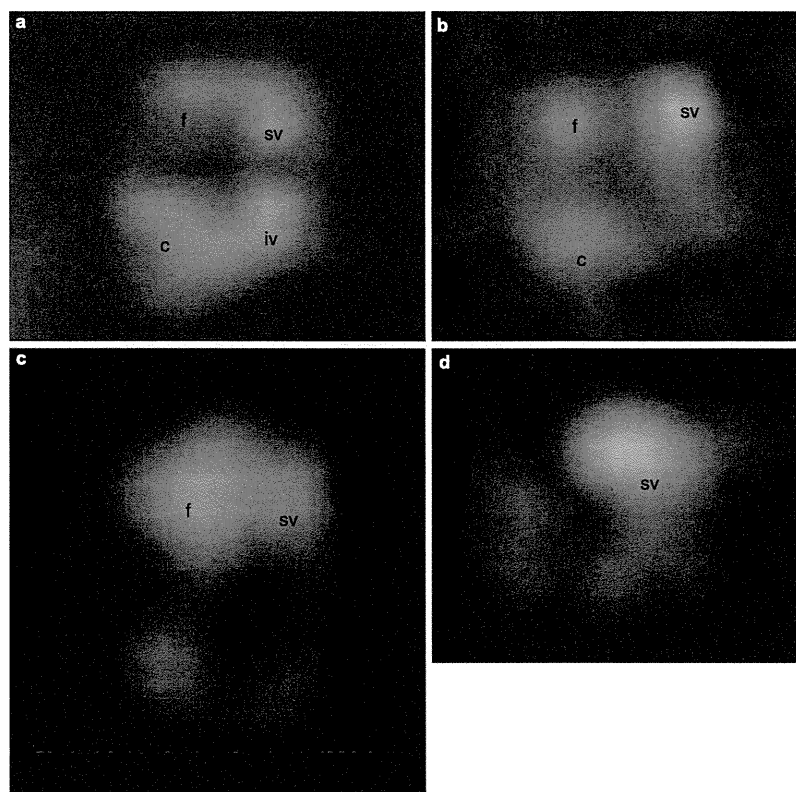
(a) Case 1: facial palsy of HB grade VI, CP, and deafness. The patient had residual dizziness and deafness that continued a year after the onset. Facial (f), superior (sv), and inferior vestibular (iv), and cochlear (c) nerves were enhanced by Gd in the internal auditory canal (IAC) on MRI. (b) Case 3: facial palsy of HB grade VI, CP, and flat type of mild sensorineural hearing loss ( $\diamond$  in Figure 1). The patient had residual dizziness and moderate sensorineural hearing loss that continued a year after the onset. f, sv, and c nerves were enhanced by Gd in the IAC on MRI. (c) Case 4: facial palsy of HB grade VI, CP, and mild high-frequency sensorineural hearing loss ( $\bullet$  in Figure 1). Her facial palsy fully recovered, and vertigo/dizziness and hearing loss disappeared within 2 months of the onset. f and sv nerves were enhanced by Gd in the IAC on MRI. (d) Case 8: facial palsy of HB grade IV, CP, and mild high-frequency sensorineural hearing loss ( $\blacktriangle$  in Figure 1). Her facial palsy fully recovered, and vertigo/dizziness and hearing loss disappeared within 2 months of the onset. Only the sv nerve was enhanced by Gd in the IAC on MRI.
